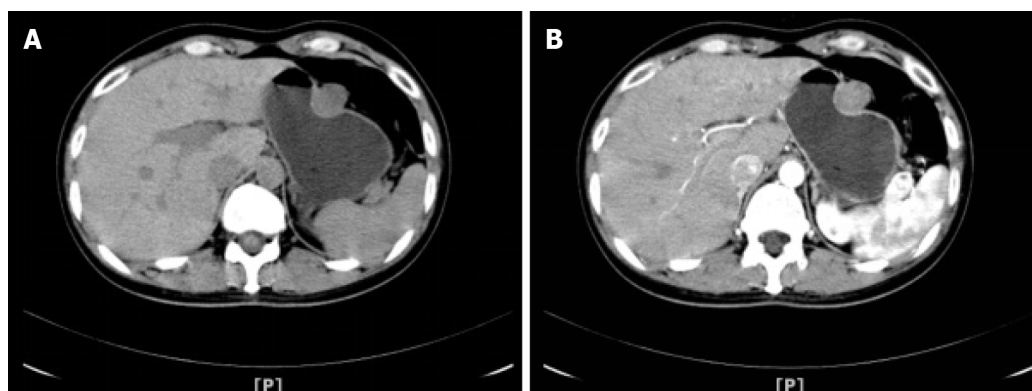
Abdominal computed tomography scanning. A: Computed tomography scan revealed a rounded mass arising from the greater curvature of the gastric body; B: The gastric mass exhibited slight internal contrast enhancement.
